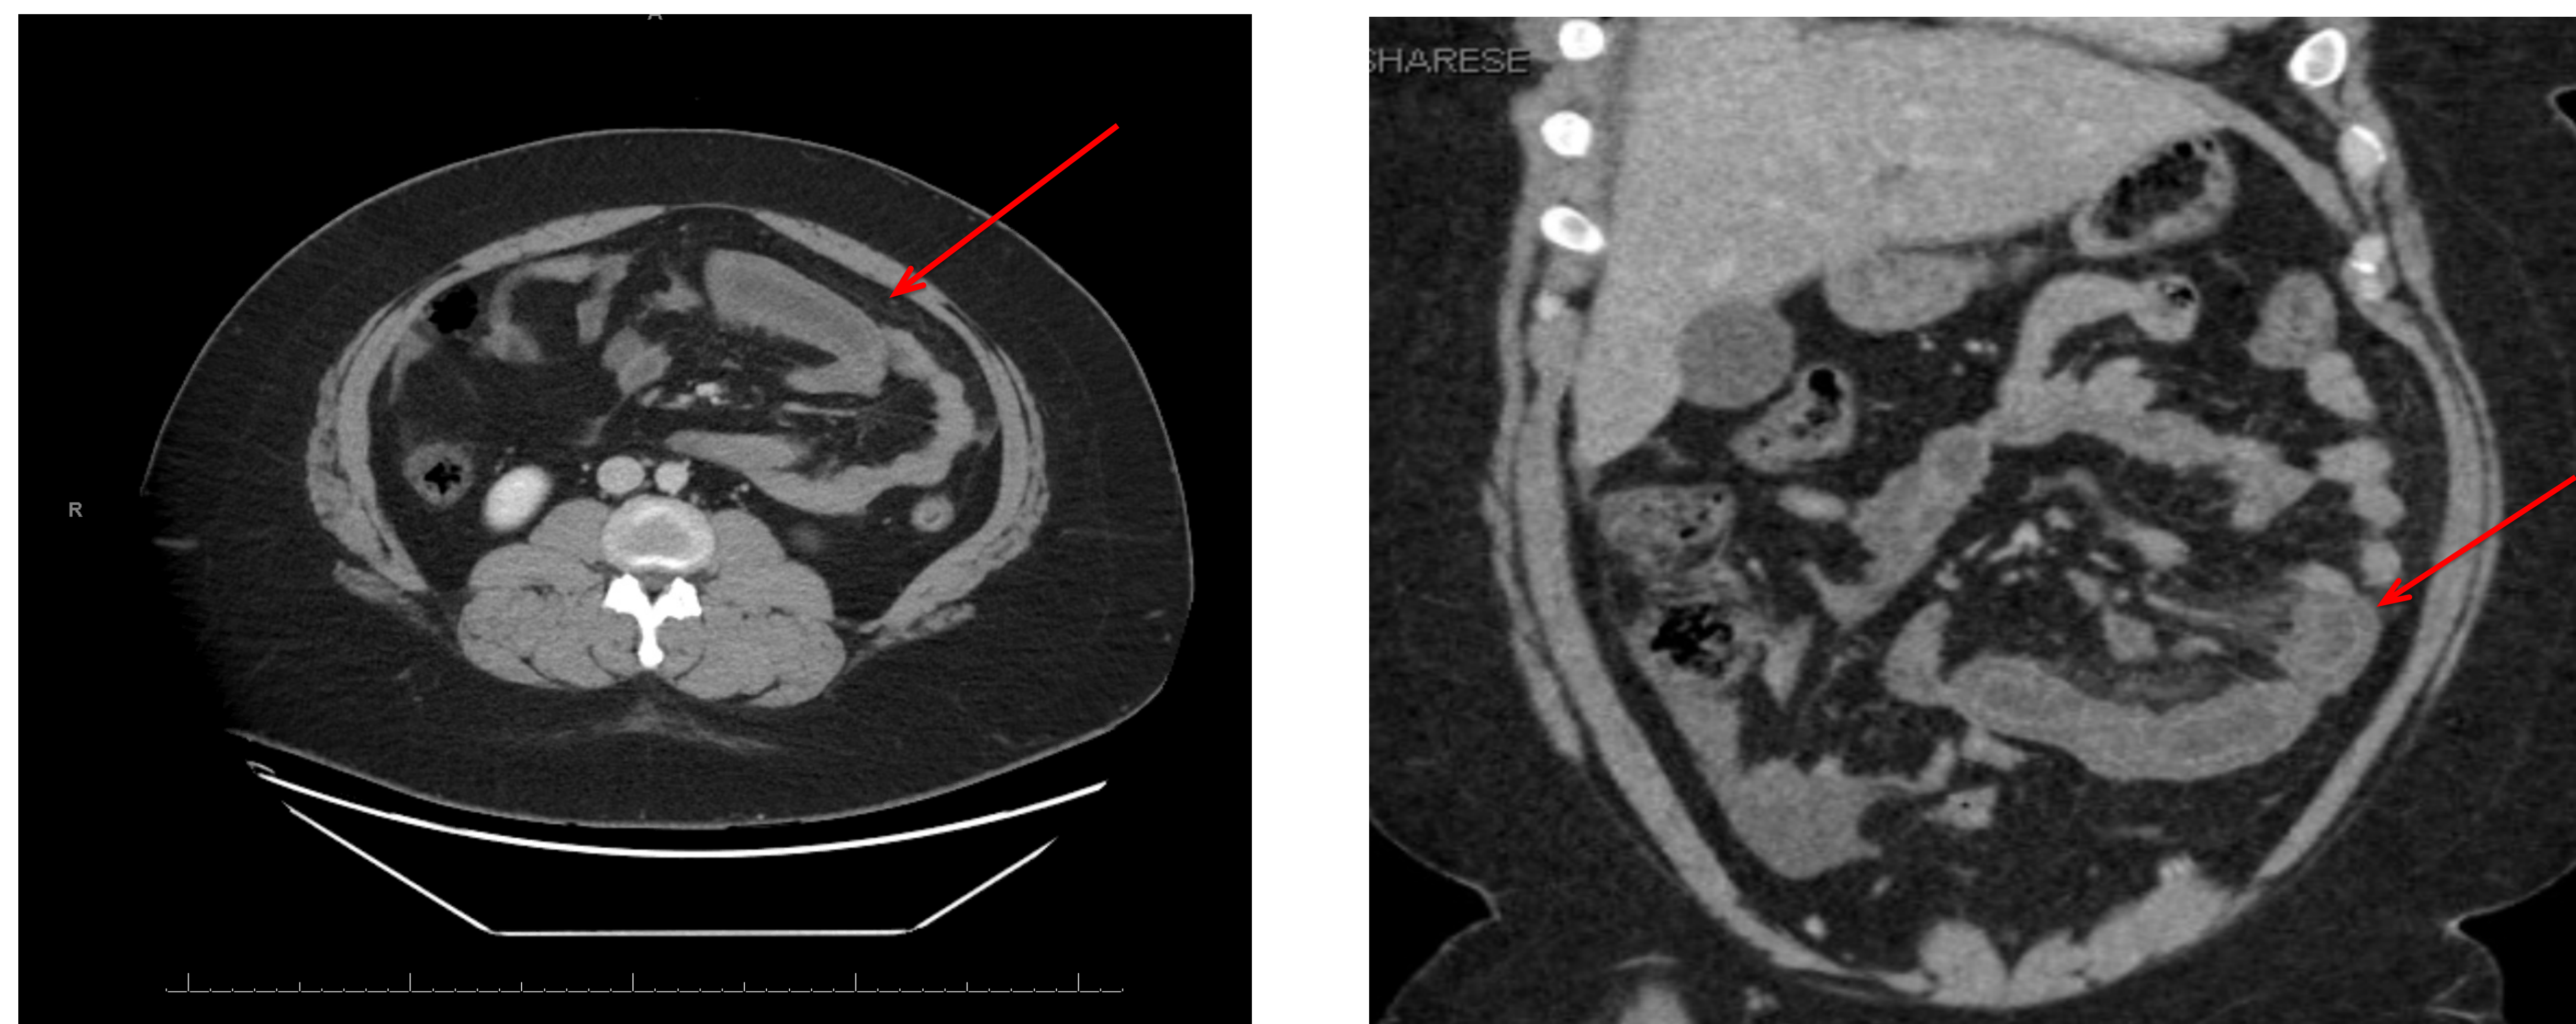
CT abdomen/pelvis positive for bowel wall thickening (indicated by red arrows).
